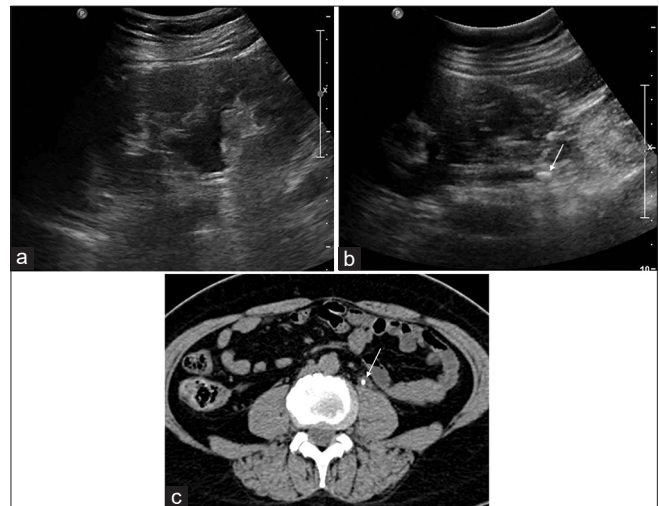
Obstructive left ureteric stone. Ultrasound (a and b) of a 57-year-old woman reveals mild hydronephrosis and proximal hydroureter with a stone (arrow) in the upper ureter. The diagnosis of left ureteric stone (arrow) is confirmed on computed tomography (c)
